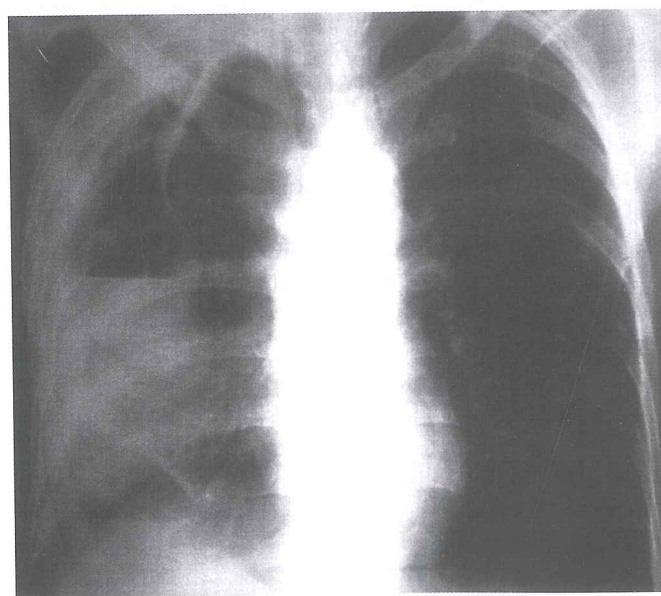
Chest X-ray showing pleural effusion reaching the hilum level.
